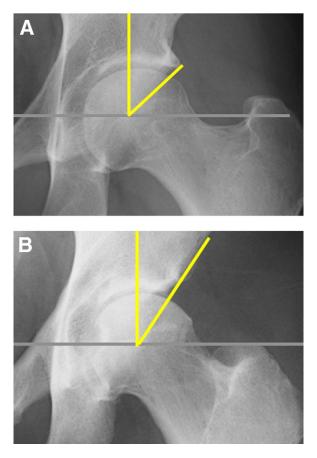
AP view of hip from a pelvis radiograph showing CE angle measurement (A) preoperatively and (B) postoperatively. The preoperative CE angle was 40° , and the postoperative angle was 33° .
